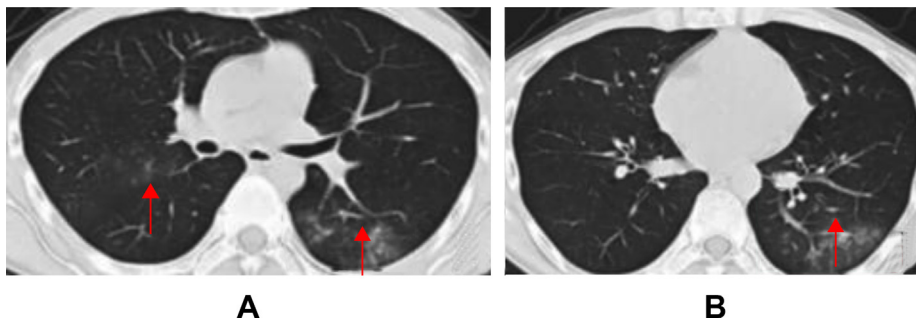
Male patient, 25 years old, fever for 4 days, no relevant contact history; CT examination; central lobular nodule and GGO in both lungs, the distribution of lesions differs from that in COVID-19 (see the red arrows).
